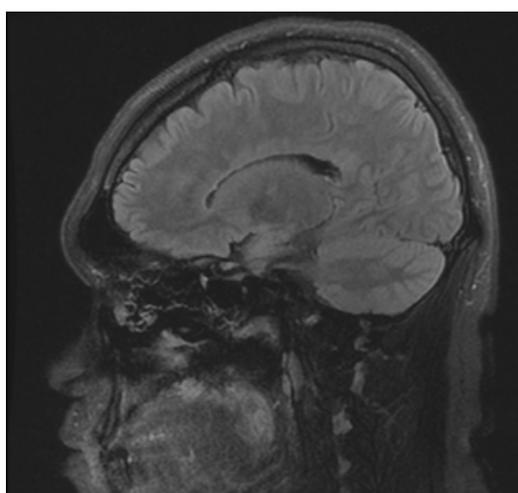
Sagittal T2-weighted image, high signal lesion perpendicular to the body of the lateral ventricles, suggestive of Dawson fingers.
